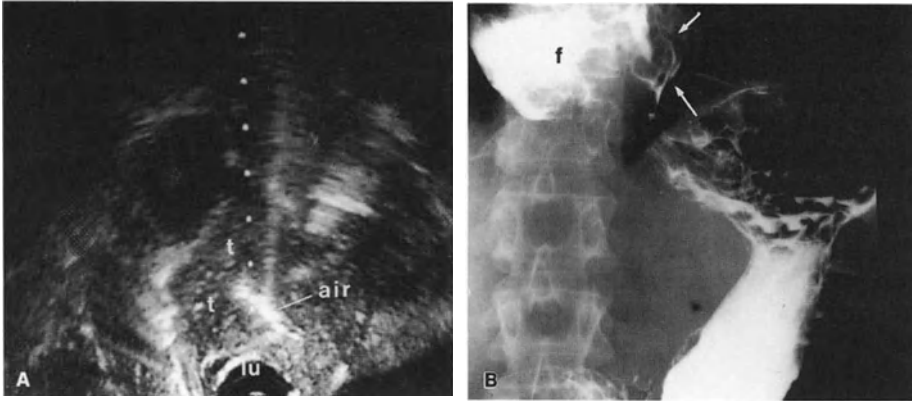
A Endoscopic sonogram showing a semicircular hypoechoic tumor mass (*t*) penetrating deeply into the surrounding tissues. The hyperechoic structures within the mass are compatible with air in the fistula. *lu*, lumen. B Corresponding radiogram, showing a polypoid lesion (*arrows*) in the distal esophagus with an extensive fistula (*f*)
